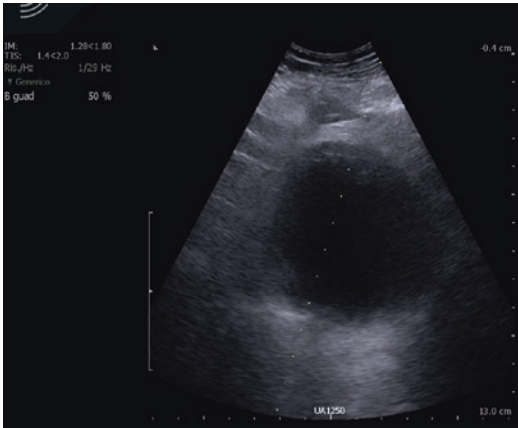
Suprapubic bladder ultrasound
